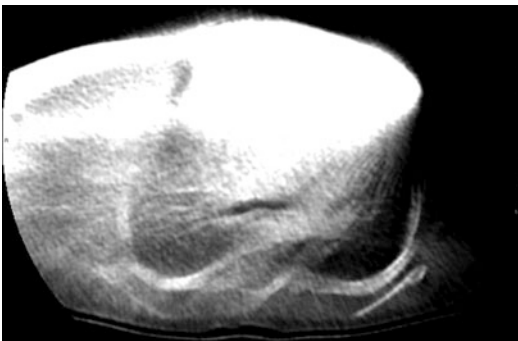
An example of streak artifacts due to a misplaced breast bismuth shielding in a thorax CT scan
